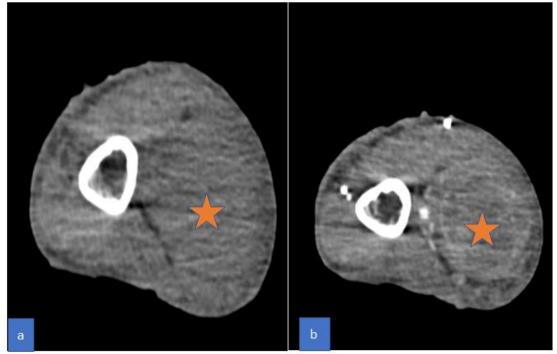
A Non contrast CT, b. Constrast CT of the right arm
